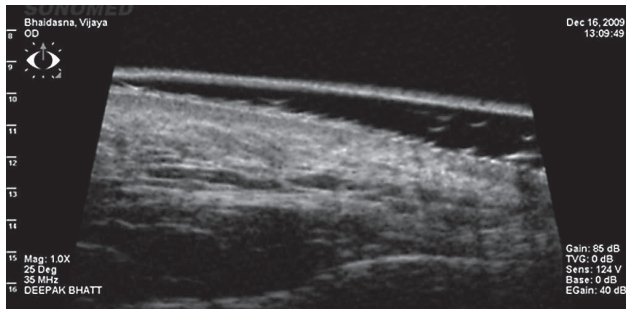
Sonography shows absence of SLEB.
